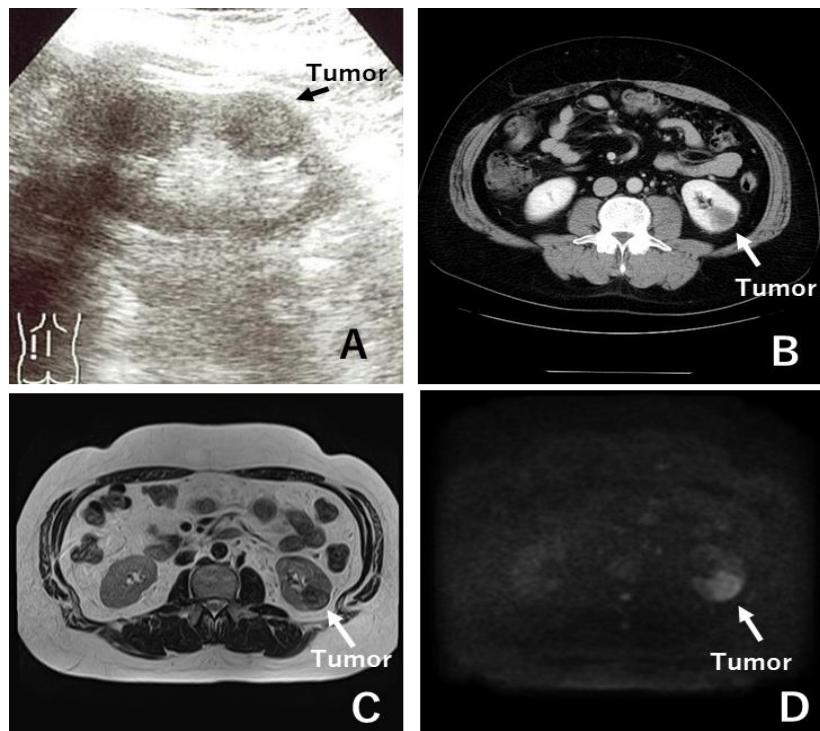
Imaging findings. Ultrasound shows mildly hypoechoic lesion in the lower pole of the left kidney (A), contrast-enhanced CT scan reveals diffusely infiltrate mass with relatively less enhancement as compared to background renal parenchyma (B), and MRI shows relatively heterogeneous hypointense on T1-weighted images (C) and increase of signal intensity on diffusion-weighted imaging (D). Arrows show tumor
